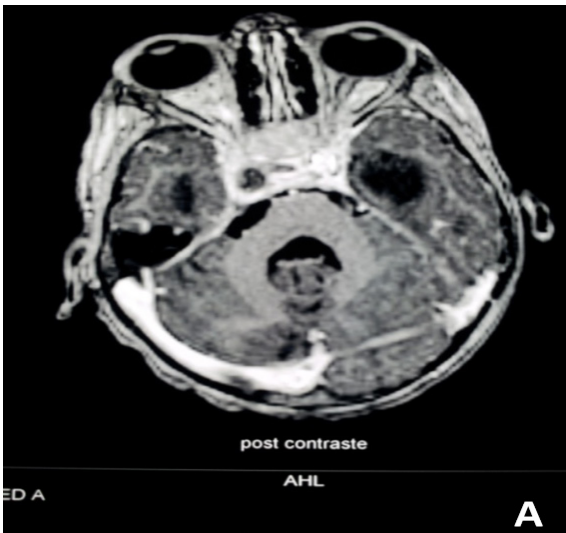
Brain MRI, Thrombosis 17 on 9 mm intense hypo of the right cavernous sinus
